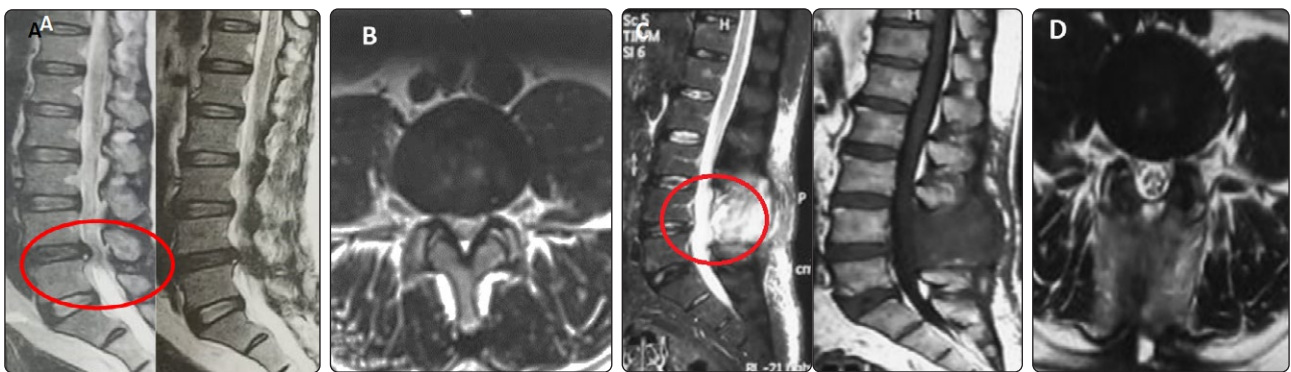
A case of L4-L5 stenosis undergoing laminectomy. (A) Preoperative MRI sagittal view. (B) Preoperative MRI axial view. (C) Postoperative MRI sagittal view. (D) Postoperative MRI axial view.
